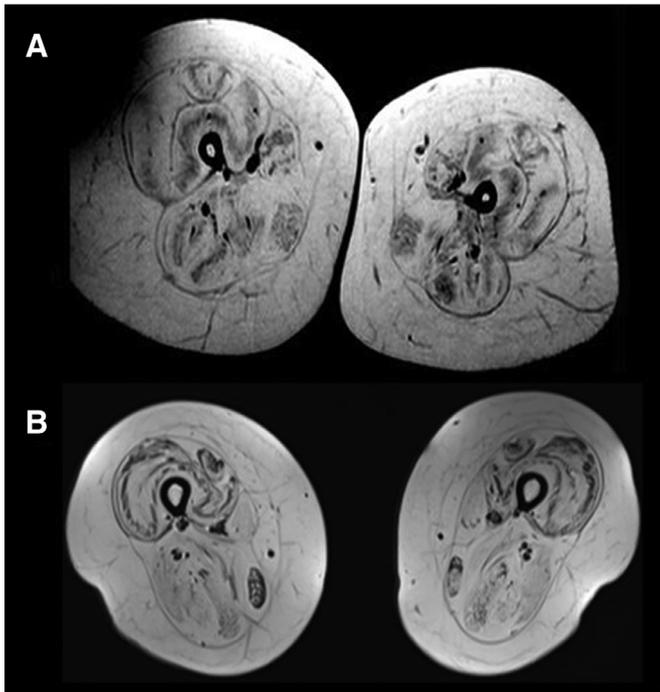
demonstrating Tigroid pattern on muscle MRI. Axial T1 weighted images at the thigh demonstrating Tigroid patterns in Ullrich (*COL6*) myopathies (Figure A) and Calpainopathies (Figure B).
